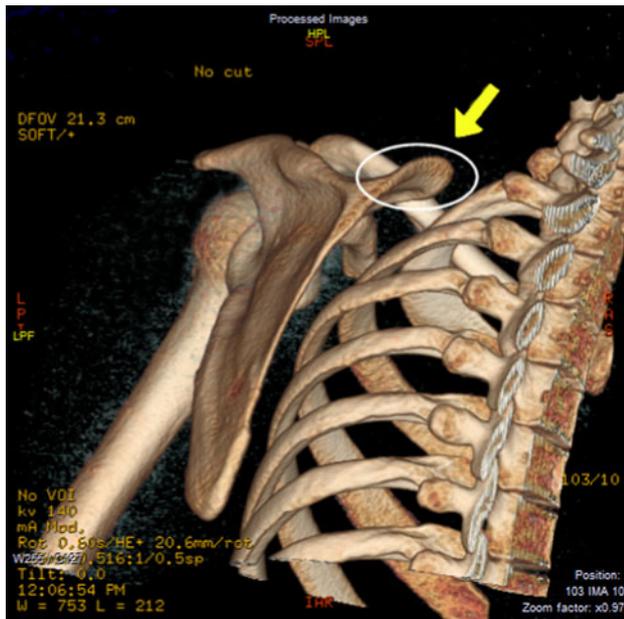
This demonstrates a normal CT scan from a patient with painful snapping scapula. The arrow points to superior medial border. The bony abnormalities are most frequent localized in this area
